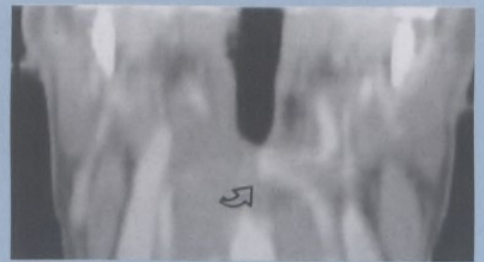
MPVR coronal CT image. The medial loop of the left internal carotid artery extends to the midline (open arrow).
